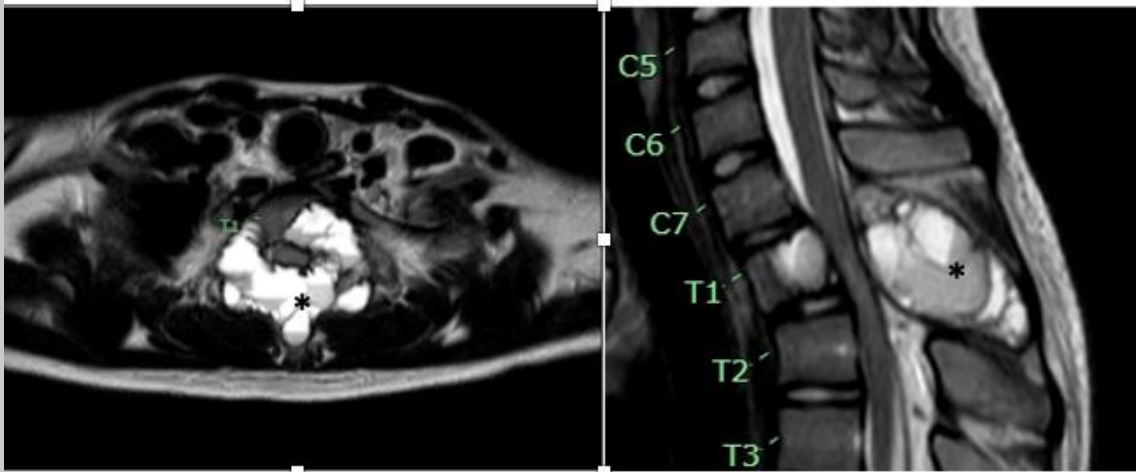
MRI scan of the thoracic spine showing multiple fluid-fluid levels involving T1 vertebral body, bilateral pedicles, lamina and spinous process –“Soap bubble” (Asterisk) with spinal cord compression
